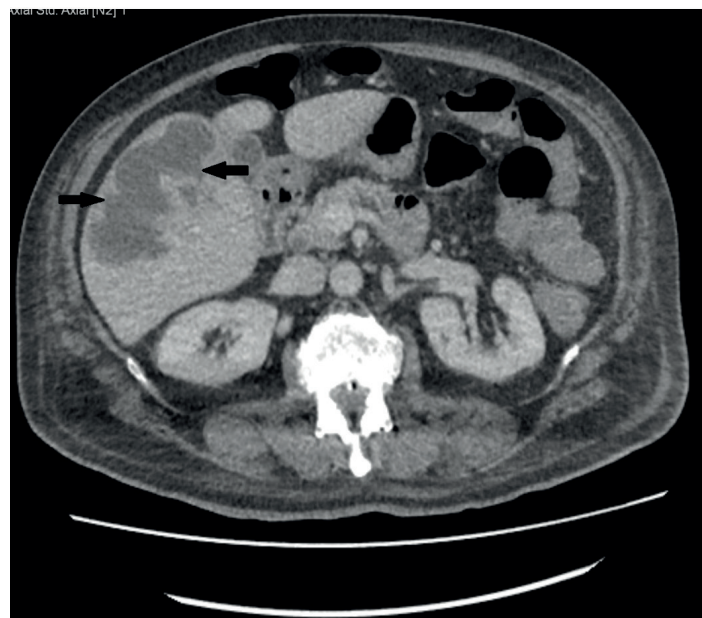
Abdominal computed tomography: an irregular limited lesion area with a contoured lobule measuring 110 × 60 mm in the right lobe of the liver (arrows).
